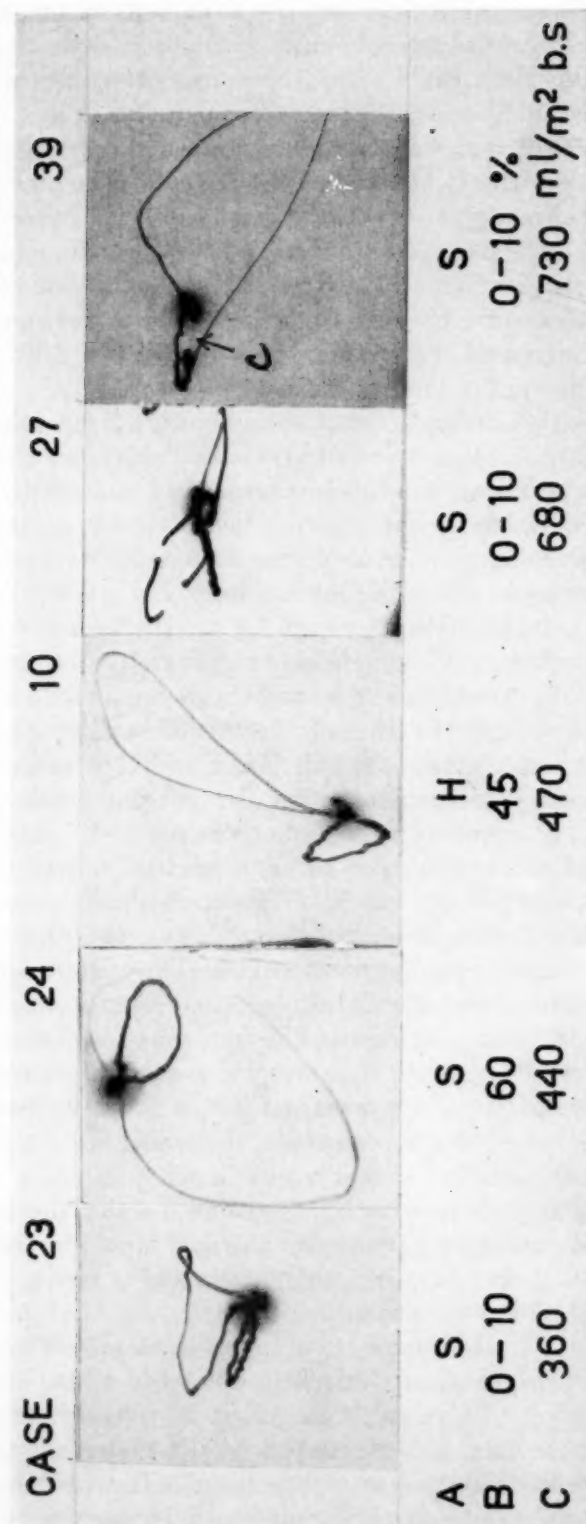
Some selected vectorcardiographic plane projections from the present series. There is a marked phase difference in the TsE loop in Cases 24 and 10, representing only slight increase in the roentgenologic heart volumes of 440 and 470 ml./M.² of body surface, respectively. No phase difference is to be observed in Case 23 with roentgenologic heart volume of 360 ml./M.², nor in Cases 27 and 39 with marked heart enlargement. In Case 39 there is, besides a discordance between the maximal vectors of the QRSsE and TsEsE loops, a noticeable potential of injury (C). A, Projection plane, B, Degree of phase difference, C, The roentgenologic heart volume.
